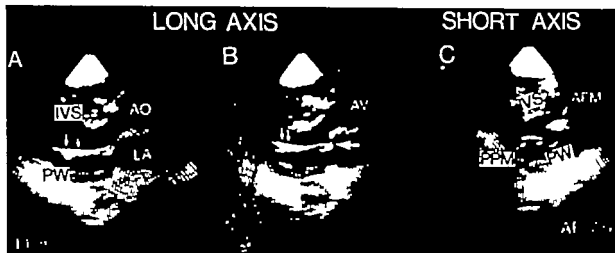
Cross-sectional echocardiograms from Case 1. Panels A and B represent long axis view frames (A mid-systole; B, late systole), and panel C short axis view frame at the level of the papillary muscles (late systole). Echoes from the papillary muscle (vertical arrows) on the long axis frames (A and B) appear abnormally dense, in relation to the interventricular septum and posterior wall, and do not shorten from panels A and B, suggesting papillary muscle fibrosis. The anterior mitral leaflet prolapses into the left atrium at late systole (panel B, large arrow). On the short axis view (C), this dense fibrotic papillary muscle is identified as anterolateral (APM). The posteromedial papillary muscle (PPM) exhibits less density than APM.
